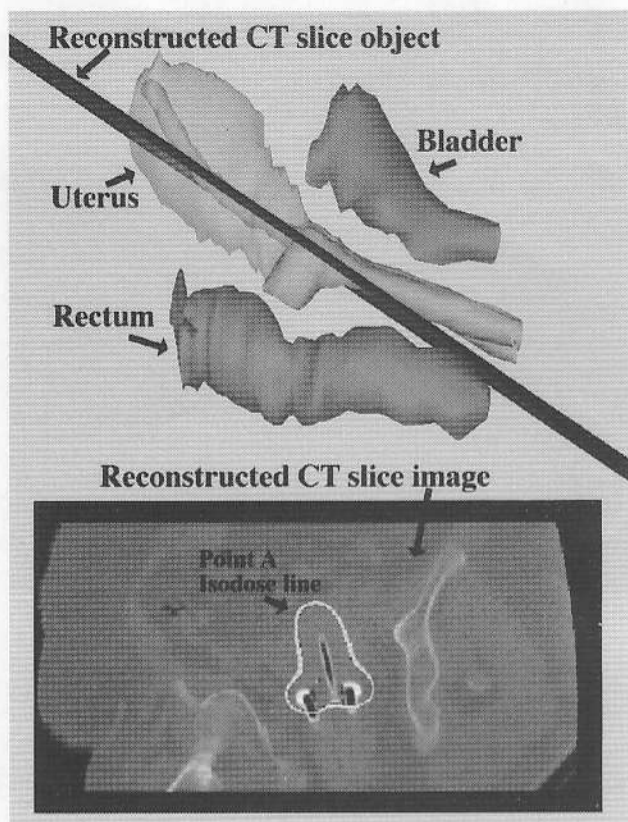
Reconstructed 3D objects from CT sections (top) demonstrate the location of the best coronal-like reconstructed CT section as a geometric object amid organ and applicator objects. Reconstructed CT image (bottom) shows the point A isodose line superimposed over the object.
